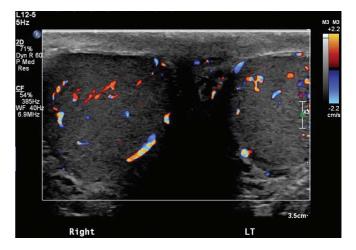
Color Doppler of bilateral testes.
